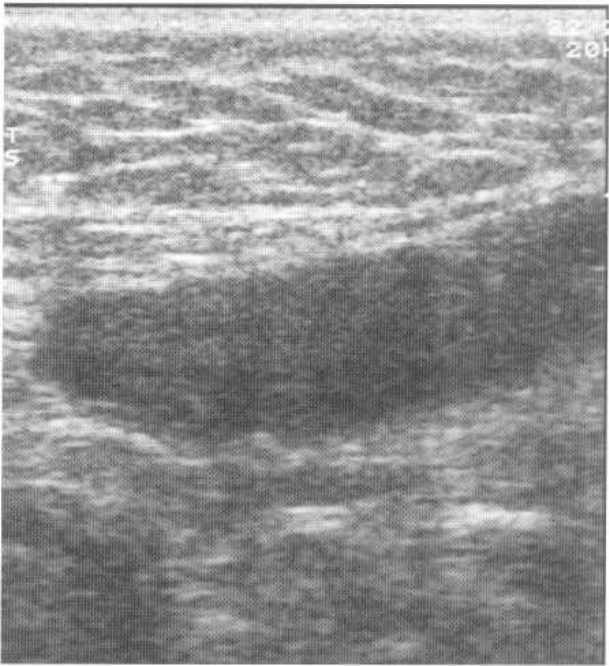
Transverse ultrasound showing an atrophic undescended testicle (arrows) lying in the inguinal canal.
